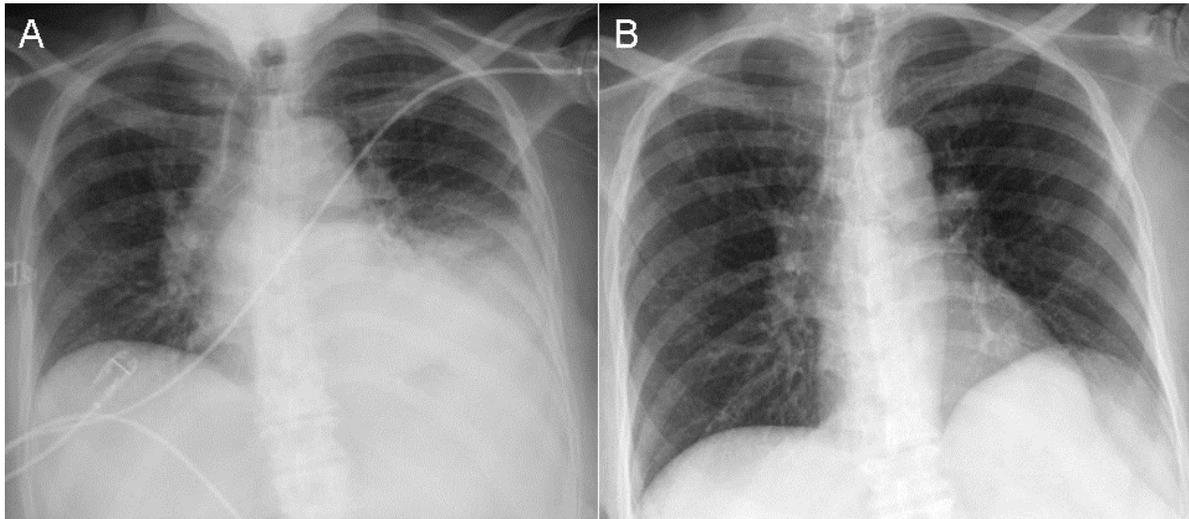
Panel A: Frontal chest radiography Panel B: Frontal chest radiograph obtained 3 months to presentation.
